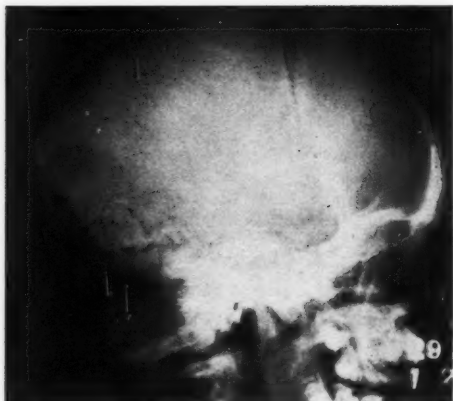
Roentgenogram of the lateral skull. Note anterior fontanelle, wormian bones, sella turcica, absence of mastoid, dental development, and small maxilla.
